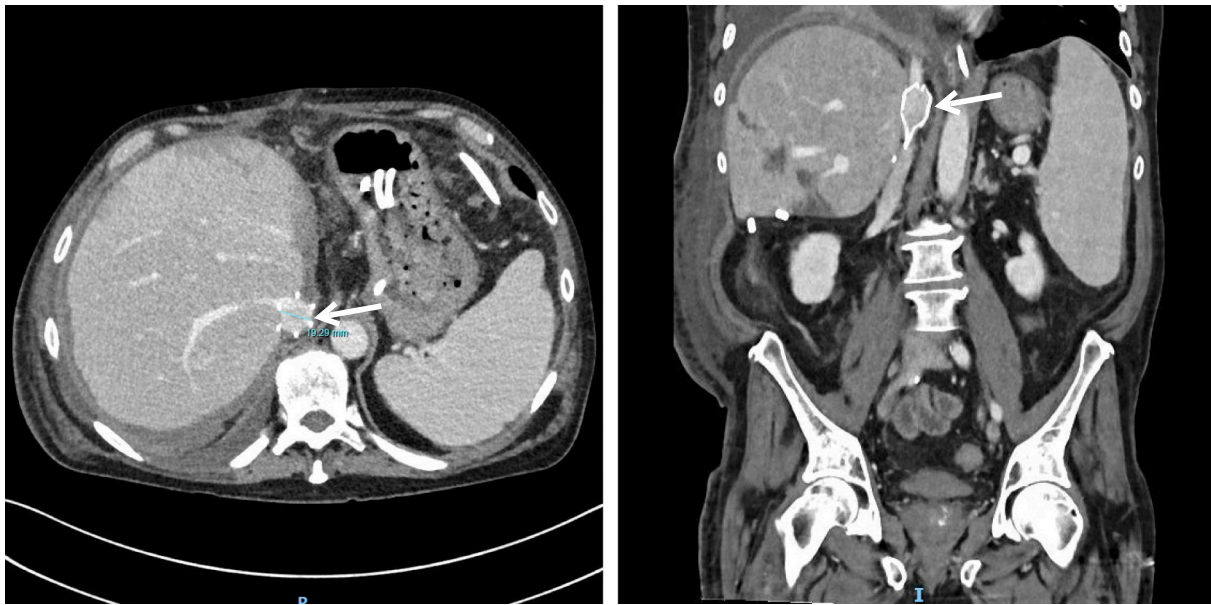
Abdominal computed tomography shows the IVC obstruction was dilated by implanting a vena cava filter (white arrow), with a diameter of 19 mm after dilation.
